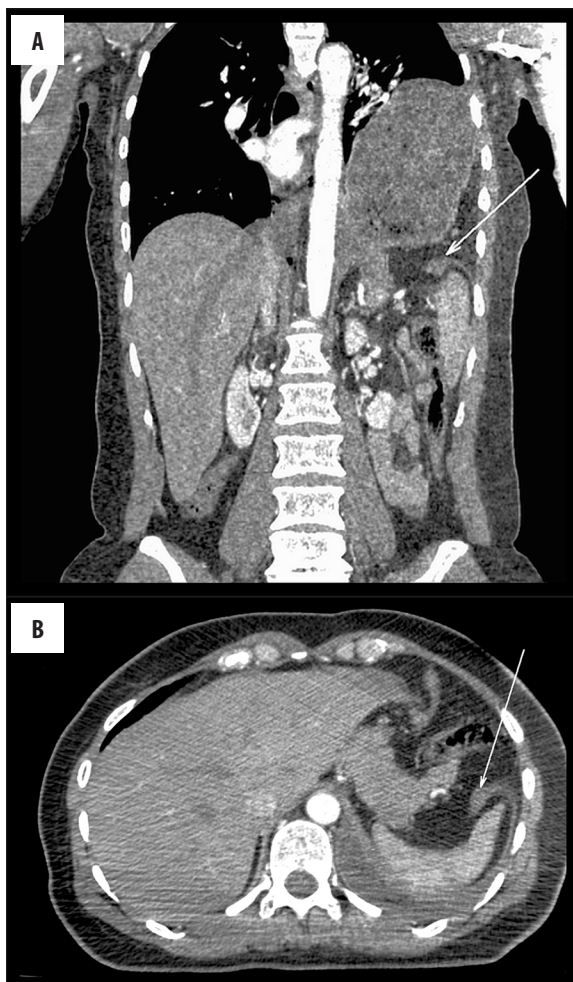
Left hemidiaphragmatic rupture in a 29-year-old man after a motor vehicle accident. Sagittal reformatted CT image shows segmental diaphragmatic defect with thickening of the diaphragm (arrow) and herniation. Left hemidiaphragmatic rupture was confirmed during surgery, with almost 75% of the hemidiaphragm being torn. Large intestine loops, stomach, part of the left lobe of the liver and omentum were herniated into the thorax. Coexisting post-traumatic changes included: subdural hematoma, fractures of the facial skeleton, instable fracture of the dens of C2, fractures of the pelvis.
